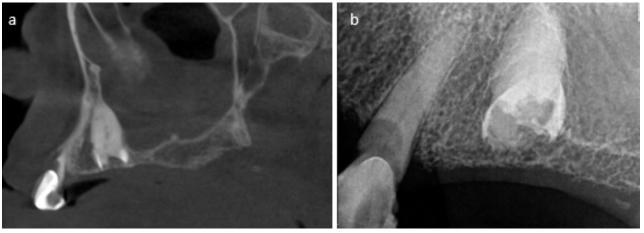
A sagittal CBCT image (a) and intra-oral radiograph (b) shows resorption of a left maxillary 2nd premolar.
